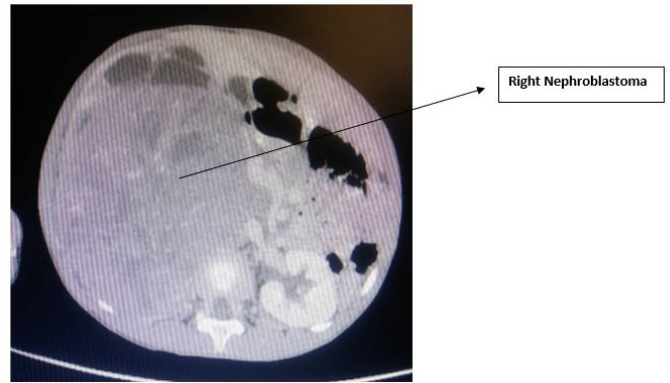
CT showing Right Nephroblastoma: A huge mixed density mass in the right renal region showing characteristic density areas suggestive of dilated calyces. The bowel loops are displaced to the left. The left kidney appears normal with prompt contrast uptake.
